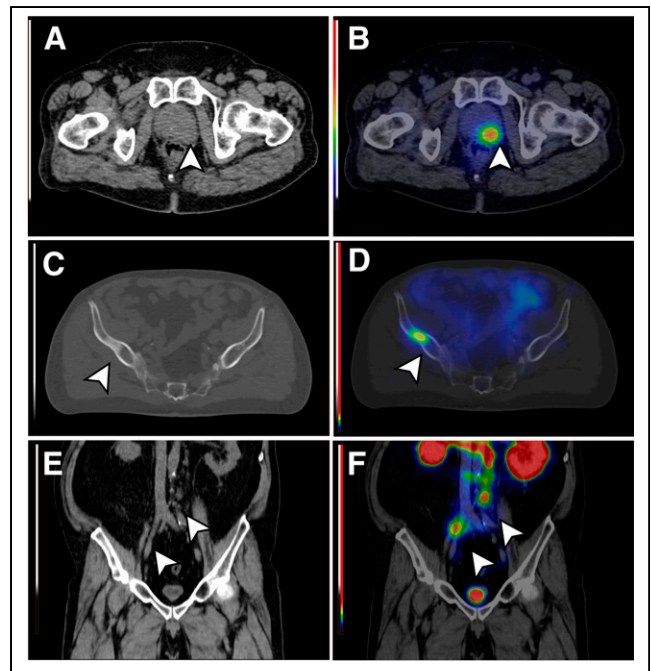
Low-dose CT (A) and ^{99m}Tc -PSMA SPECT/CT (B) images of a PCa primary tumor lesion (patient 012) with high TBR (SUV_{max}: 22.00, TBR: 42.30 [arrowheads]). Low-dose CT (C) and ^{99m}Tc -PSMA SPECT/CT (D) images of a PCa bone metastasis (patient 011) with high TBR (SUV_{max}: 11.89, TBR: 25.85 [arrowheads]). Low-dose CT (E) and ^{99m}Tc -PSMA SPECT/CT (F) images of PCa LN metastases (patient 014) with high TBR (SUV_{max}: 8.23, TBR: 23.51 and SUV_{max}: 8.48, TBR: 24.23 [arrowheads]).
